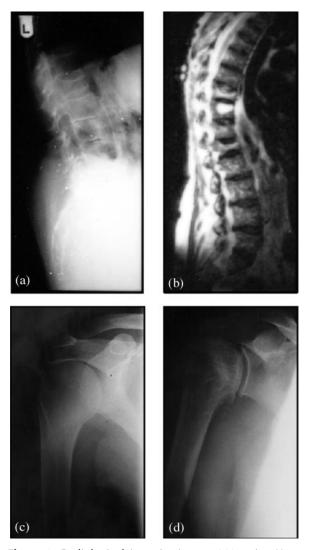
Radiological investigations. a M1: spine X-ray showing vertebral crush fractures. b M1: spine MRI showing vertebral crush fractures and bone marrow infiltration by Gaucher cells. c D1 (unaffected twin): X-ray of right shoulder. d D2: X-ray of right shoulder showing avascular necrosis of the humeral head.
